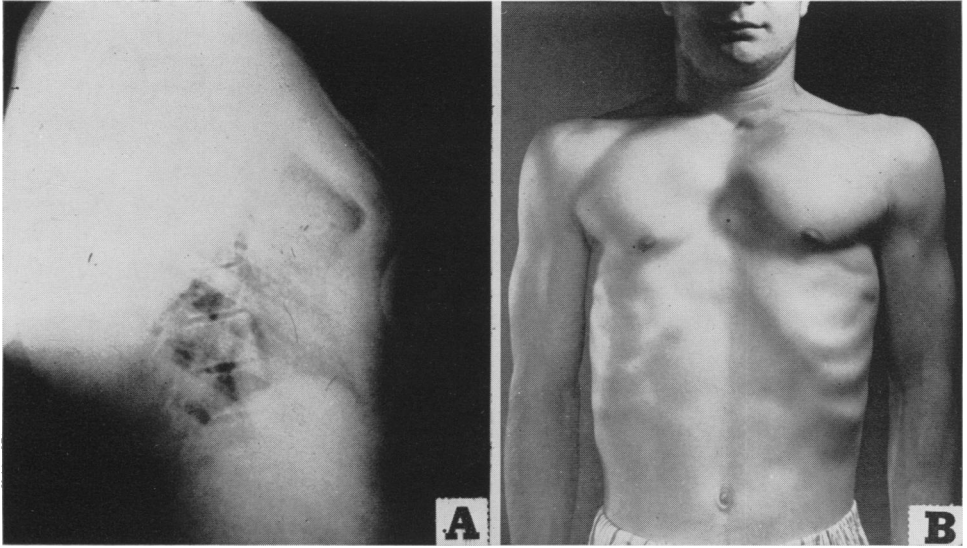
B.R.—18-year-old college student, with attacks of palpitation followed by apparent slowing of the heartbeat, and heavy breathing. (From the *Journal of Thoracic Surgery* 23: 138–144, 1952) A and B a peculiar conformation of the chest—the manubrium slopes broadly forward to the manubrio-gliadiolar junction, where there is a sharp posterior angulation. From this point the gliadiolus inclines posteriorly to the lower third of the corpus sternali, where the slope reverses itself and the sternum tilts anteriorly. Both the photograph and the roentgenogram show the abnormal prominence of the manubrium associated with a depression of the corpus sternali.
